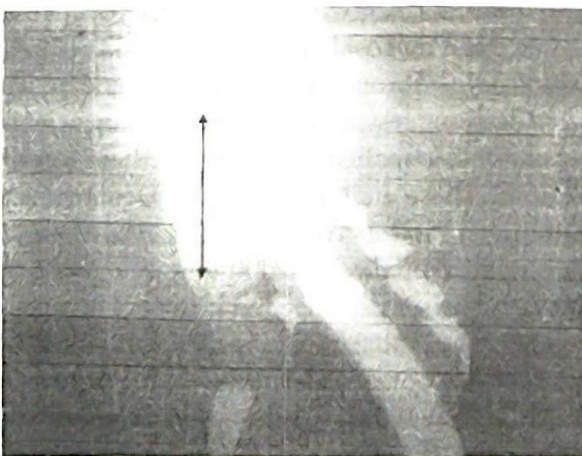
CT scan of the neck with the arrow showing extensive stenosis involving the larynx and trachea with grade IV, complete (100%) obstruction of the airway.
